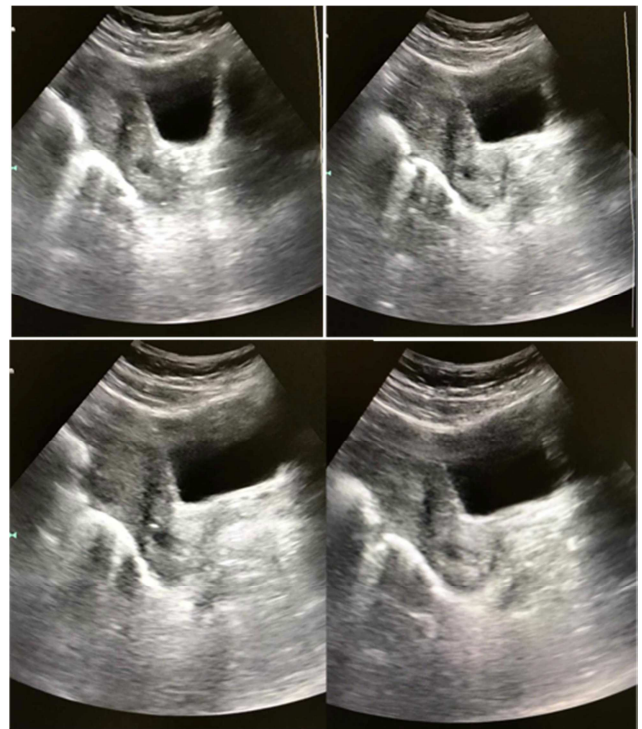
Images of CEP on day 4 methotrexate by pelvic ultrasound (abdominal approach).
